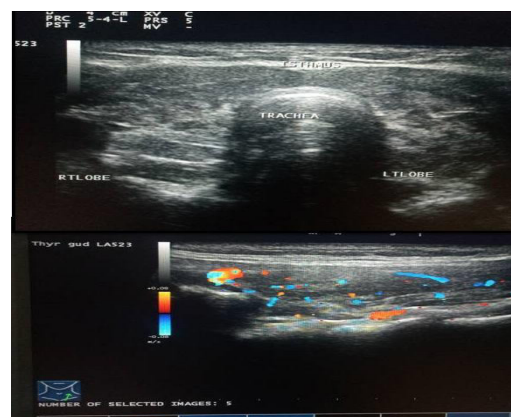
Neck ultrasound showing the typical appearance of Hashimoto Thyroiditis on ultrasound.
